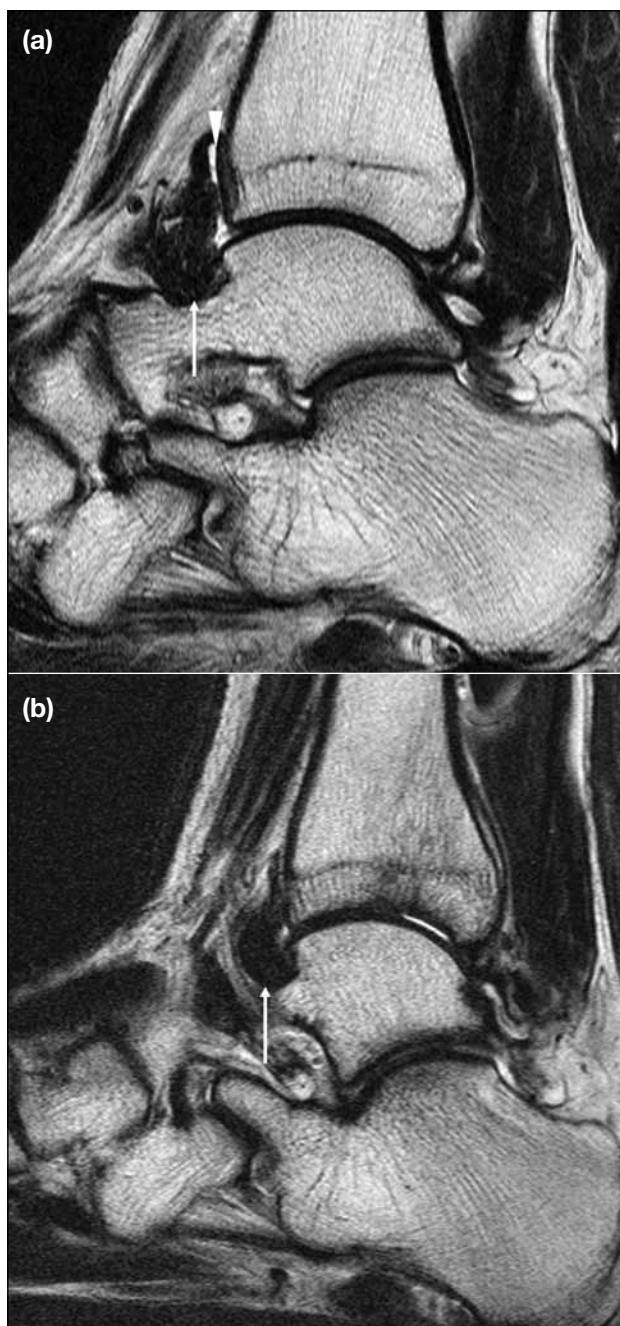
Sagittal T2-weighted magnetic resonance imaging ankle (a) before synovectomy shows severe synovial thickening in the anterior recess of the ankle (white arrow); this is associated with mild ankle joint effusion (arrowhead), and (b) 12 months after synovectomy shows decrease in synovial thickening in the anterior recess of the ankle (white arrow); the mild ankle joint effusion has largely resolved.
